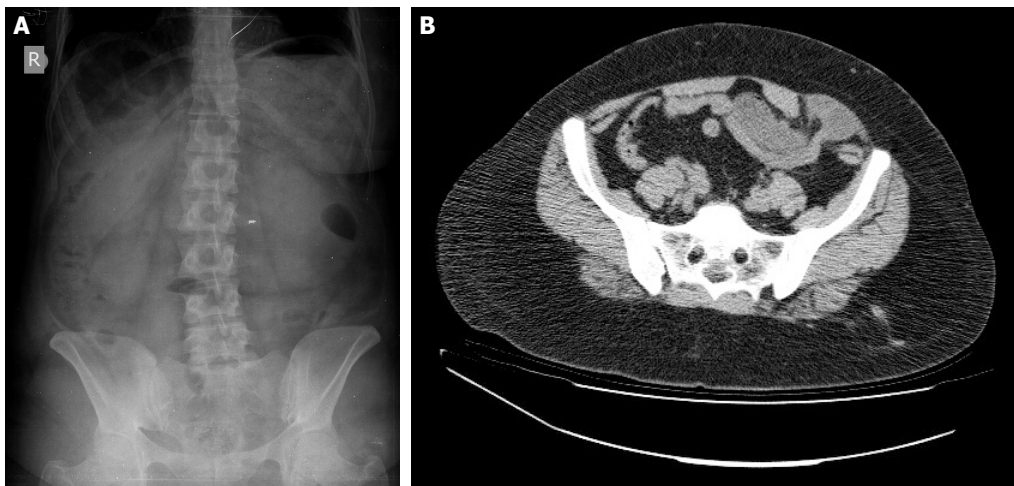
(A) Direct abdominal x-ray at a standing position. (B) Appearance of the incarcerated intestinal loop on Abdominal CT.
